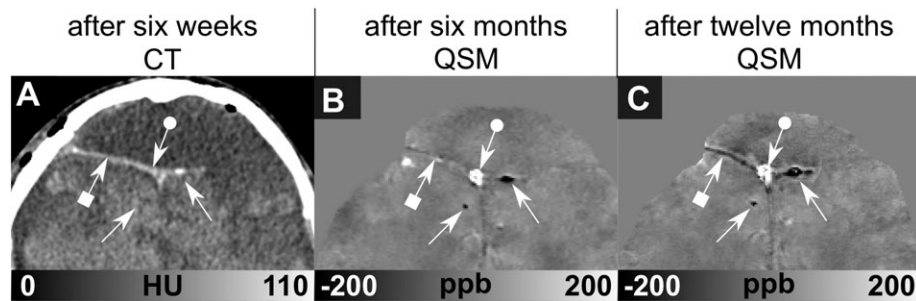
Case of a 2.5-year-old boy who survived a severe traumatic brain injury after falling from a height of 6 m. (A) Computed tomography (CT) scan 6 weeks after the injury. Susceptibility maps of the same slice after 6 months (B) and after 12 months (C). CT (A) confirmed post-traumatic formation of the bifrontal hygroma and discrete calcification [107 Hounsfield units (HU); right-hand-side straight-ended arrow]. Quantitative susceptibility mapping (QSM) delineates several smaller collections of blood (circle-ended arrow) as well as punctate calcifications of the dura mater and adjacent to it (straight-ended arrows). Although the dura mater (square-ended arrow) appeared both isointense and slightly hyperintense on the susceptibility map during the initial MRI (B), it appeared with low intensity on the susceptibility map acquired 12 months after the injury (C), suggesting incomplete blood removal and calcification.
